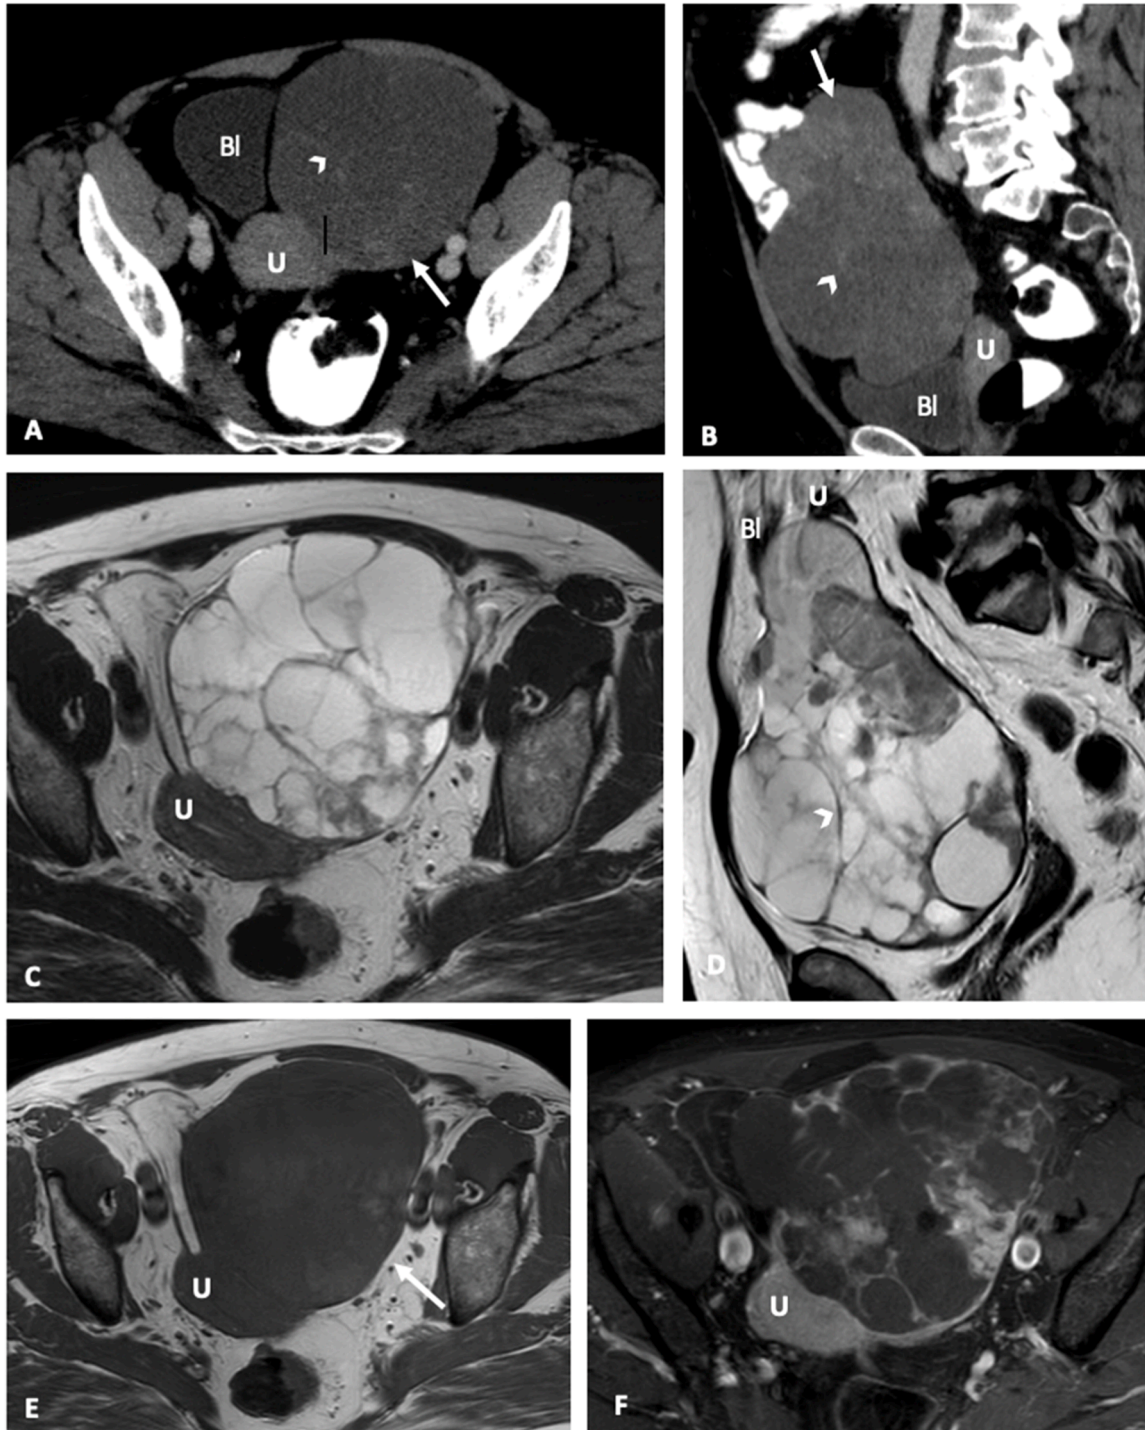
OCCC in a 64 years-old woman with a pelvic mass incidentally found on a routine ultrasound examination. A, Axial (A) and sagittal (B) contrast-enhanced CT portray a large well-defined multilocular cystic mass with many irregular parietal solid protrusions (arrows) and thin septations (arrowheads), suspicious. C, D Axial (C) and sagittal (D) T2WI showing a large, well-defined multilocular cystic mass with a multifocal irregular lumen protruded intermediate SI solid nodules and many irregular and thin septations. The septations were < 3mm in thickness (arrowhead). E, Axial (E) T1-WI shows a predominantly hypointense mass. The solid portion had intermediate SI on T2WIs and hypointense SI on T1WI (arrows). The SI of the cyst was high on T2WIs and low to intermediate on T1WI. F, Axial contrast enhanced T1WI with FS exhibits a strong heterogeneous enhancement of solid mural nodules with central non-enhanced cystic areas. In surgery, the left ovary was occupied by a 12cm in the largest dimension, that was solid and cystic intraovarian tumour. U – uterus; Bl – bladder.
